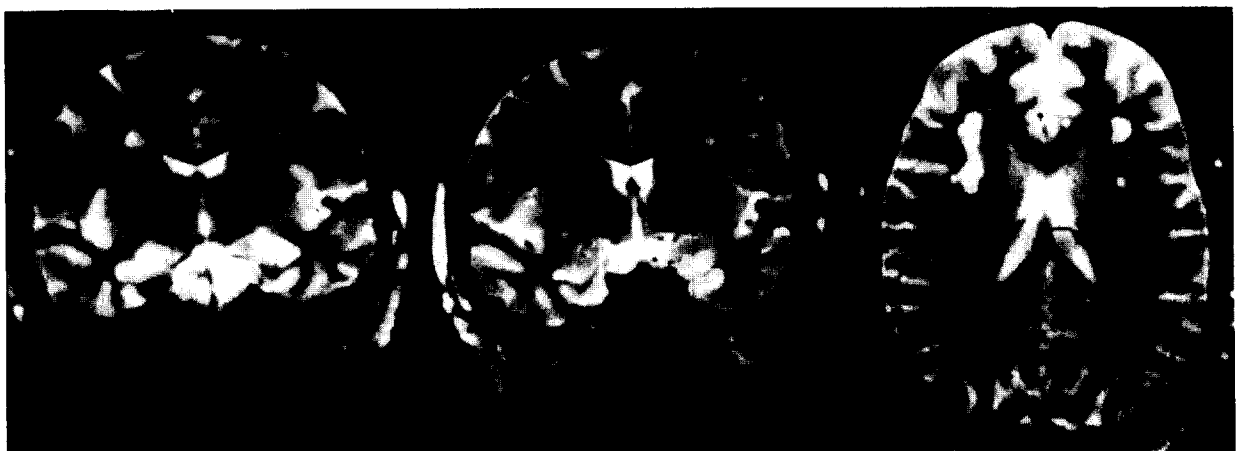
MRI, T₂-weighted images of a patient who had sustained a mild concussion.
